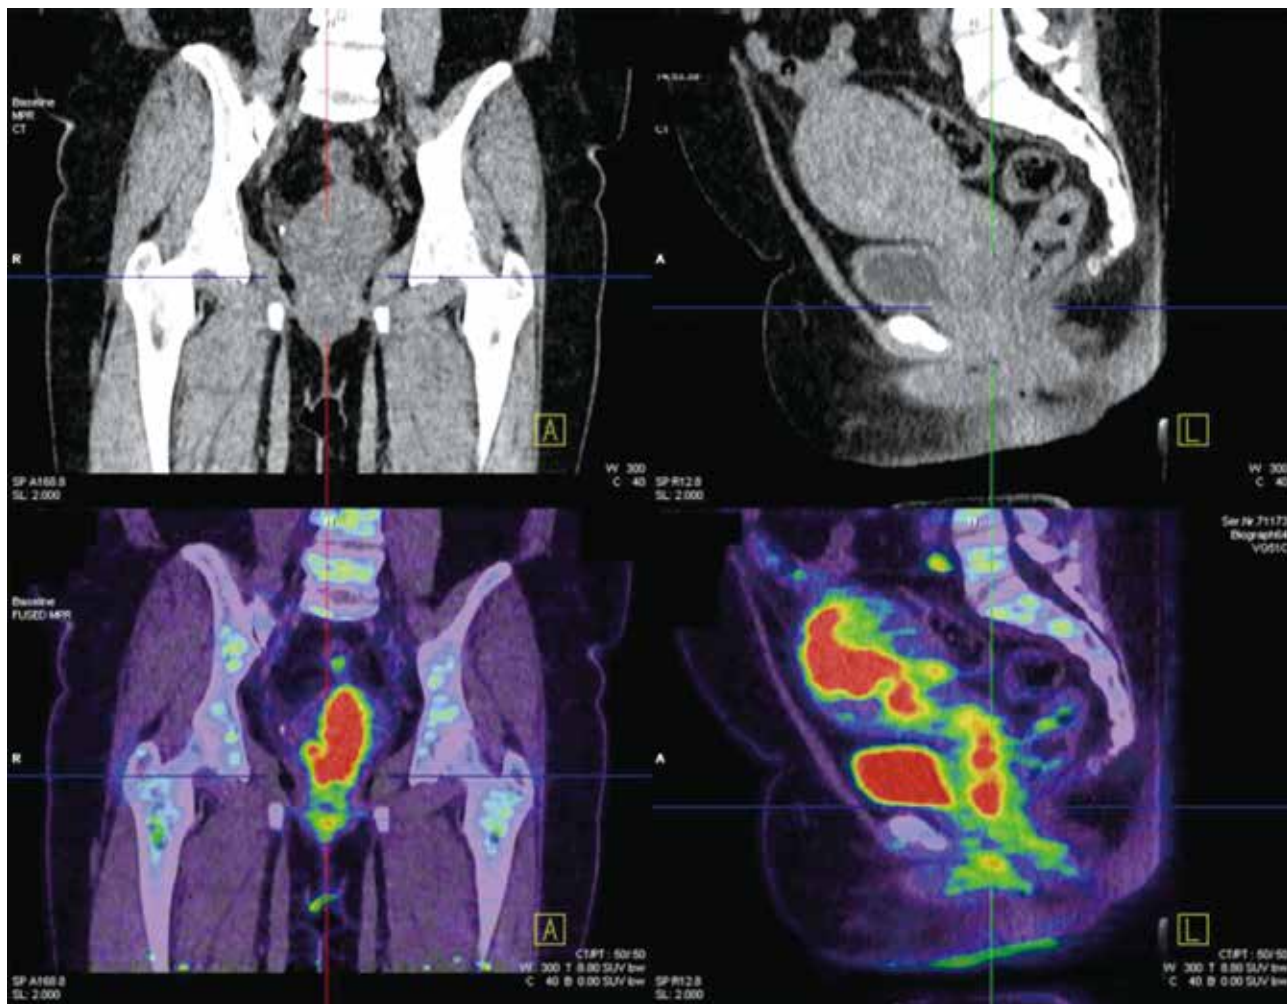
¹⁸F-FDG PET/CT 掃描發現子宮頸癌侵犯子宮頸、陰道及子宮本體
